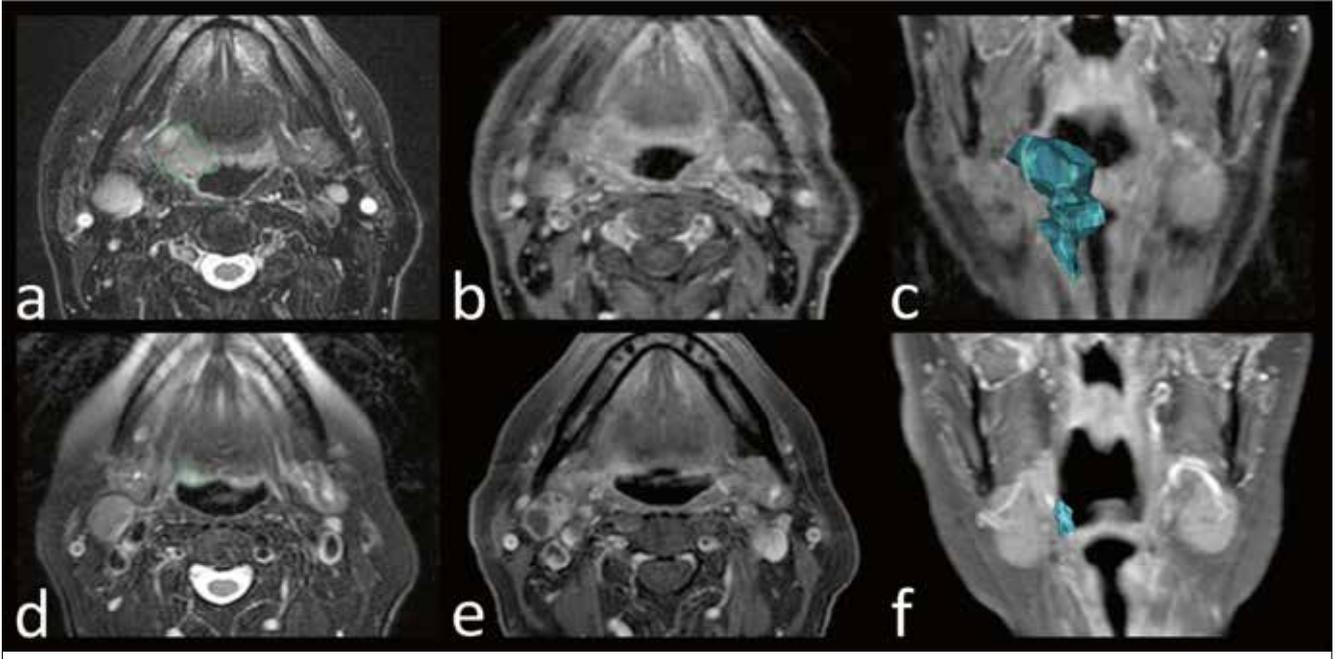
Volumetric assessment of primary tumour volume. Squamous cell carcinoma of the oropharynx in a 73-year-old man. (a,d) Axial fat-saturated T2-weighted MR images. (b,e) Axial post-contrast T1-weighted fat-saturated MR images. (c,f) Coronal post-contrast T1-weighted fat-saturated MR images with 3D volumetric tumour reconstructions. Before induction chemotherapy (a,b,c): MR images show expansive/infiltrative tissue centred on the right glossopharyngeal fold, hyper-intense on T2-weighted image (a) with slight and faint enhancement on post-contrast T1-weighted fat-saturated MR image (b). The lesion was manually outlined (green closed line in a) to obtain a volumetric reconstruction of the tumour (blue volume in c). After induction chemotherapy (d,e,f) MR images show significant volumetric reduction of the lesion.
